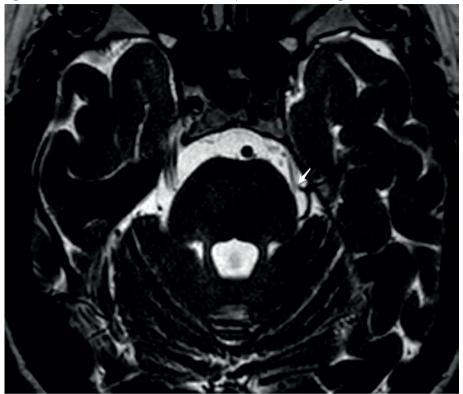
MRI brain before microvascular decompression of the left trigeminal nerve
